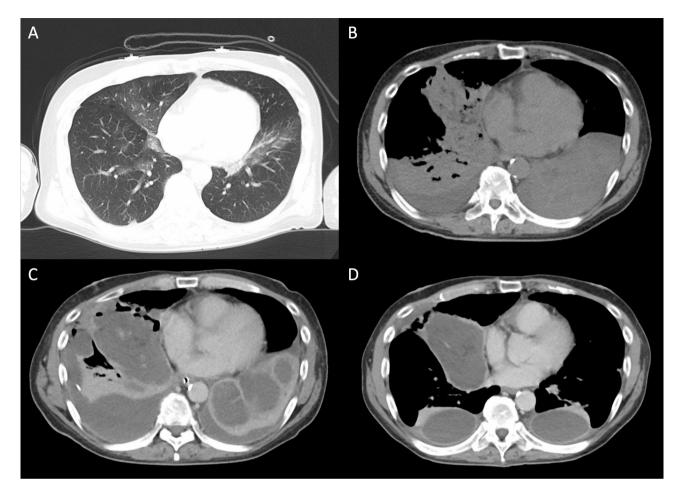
CT scans obtained during pneumonitis and evaluation of lung abscess. A Ground-glass opacities in the right middle lobe and bilateral lower lobes on hospital arrival, suggesting chemical pneumonitis. B Bilateral diffuse atelectasis and pleural effusion in the dorsal side of both lungs on day 4. C Multiple lung abscesses detected in the right middle lobe and left lower lobe on day 13. D Follow-up CT scan showing improvement of lung abscess on day 45
